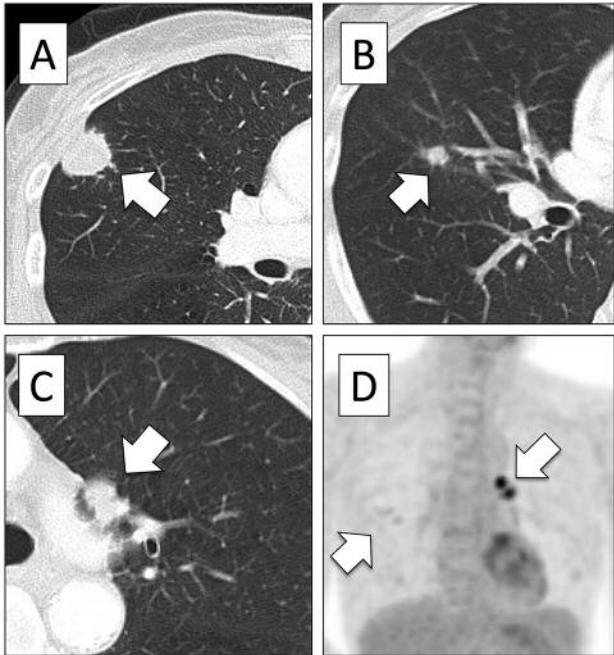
Computed tomography (CT) showed a 18 mm tumor (A) and a 7 mm tumor (B) of the right middle lobe (RML). A 10 mm tumor was also determined in the left upper lobe (LUL). Positron-emission tomography/CT showed mild uptake of fluorodeoxyglucose at tumors of the RML (maximum standardized uptake value [SUV_{max}]=1.50) (C), and avid uptake at the LUL (SUV_{max} =8.49) and left hilar lymph node (SUV_{max} =7.16) (D).
